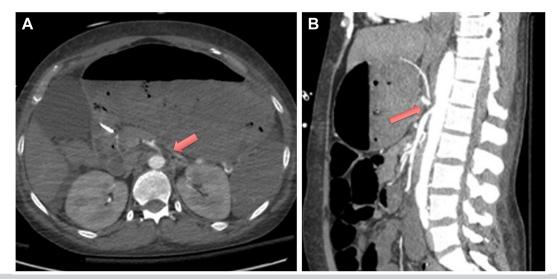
Transverse (A) and sagittal (B) sections of computed tomography angiography showing >90% stenosis of the celiac artery (CA) origin (*red arrow*) with "trace string-like attenuation."
